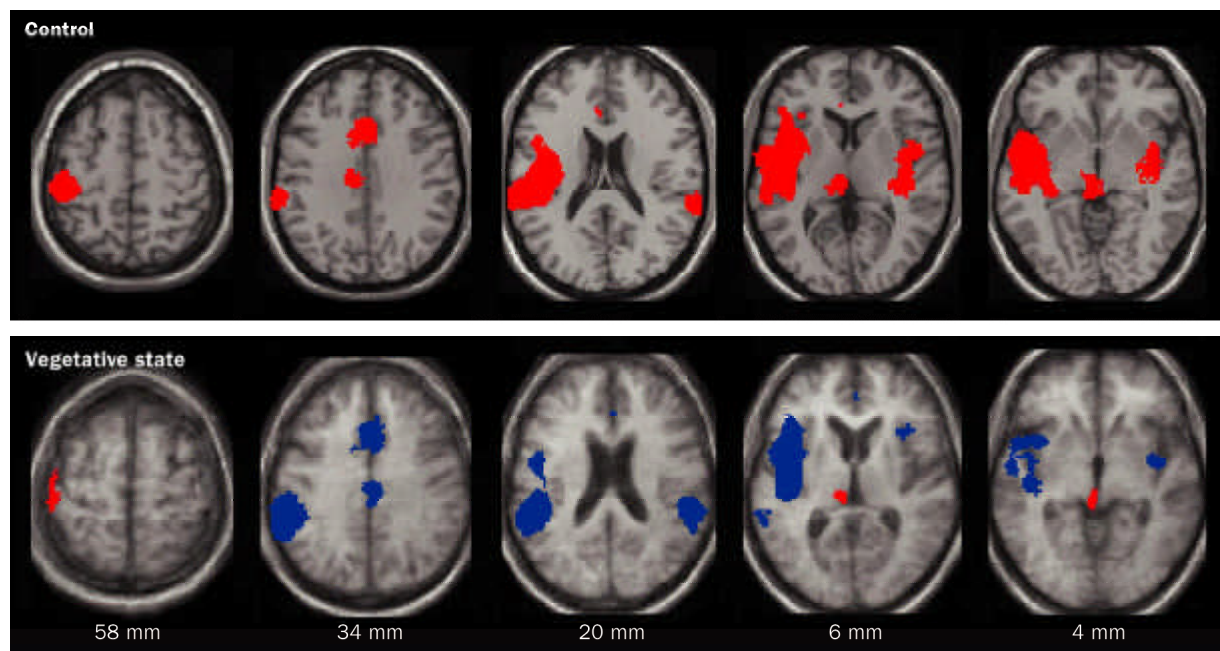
Pain perception in vegetative state. Top: Brain regions that were activated during noxious stimulation in controls are shown in red. Bottom: Brain regions that activated during stimulation in patients in vegetative state are shown in red and regions that activated less in patients than in controls are shown in blue. Regions of activation are projected on transverse sections of a normalised brain MRI template in controls and on the mean MRI of the patients (distances are relative to the bicommissural plane). Reproduced with permission from Elsevier.<sup>69</sup>
